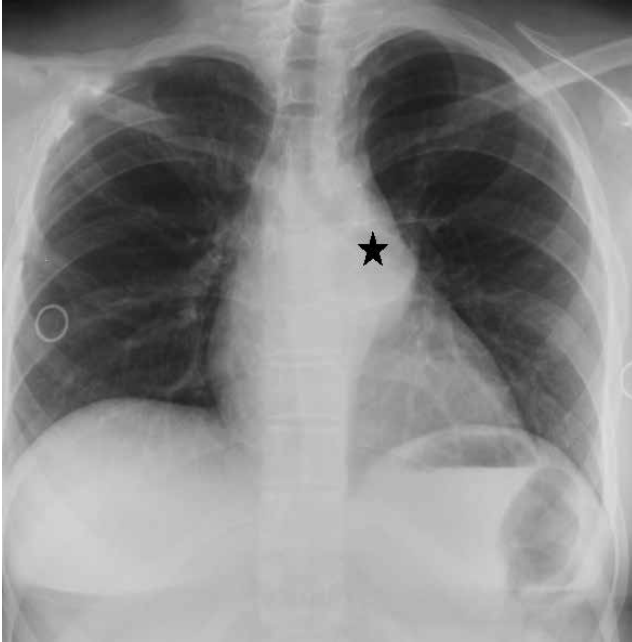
Chest X-ray demonstrated a paravertebral mass behind the heart (star).
